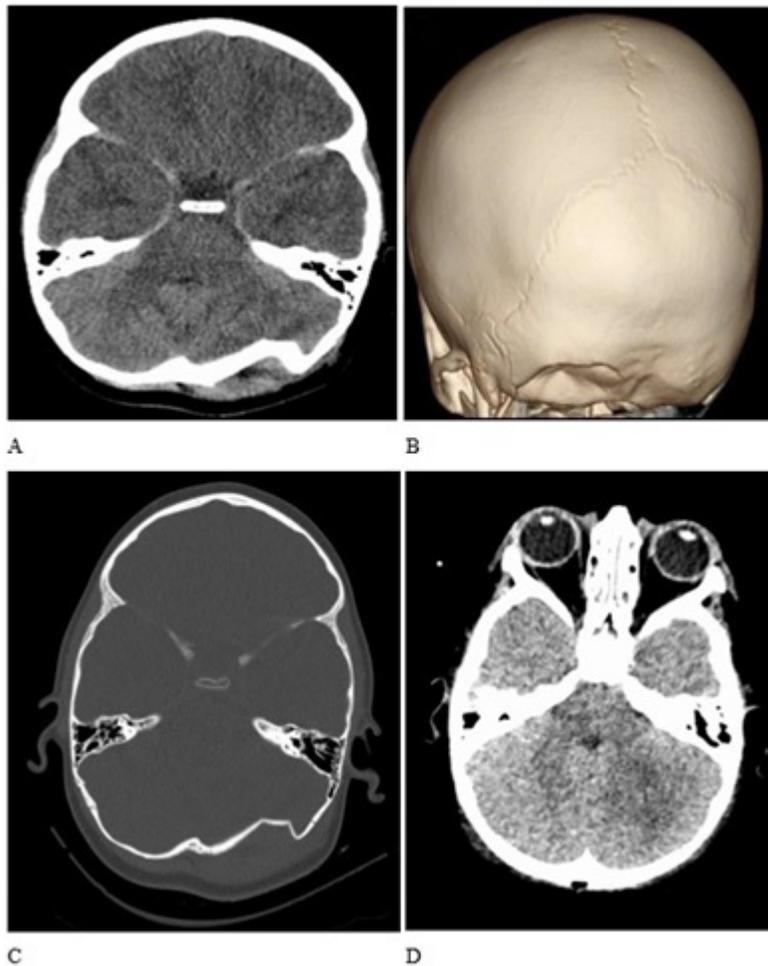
Computed tomography of the head depicting an infratentorial “ping pong” fracture of the left-sided suboccipital bone (A - C). Diffuse brain swelling in the posterior fossa with consumed basal cisterns and some compression of the fourth ventricle can be noted (D)
